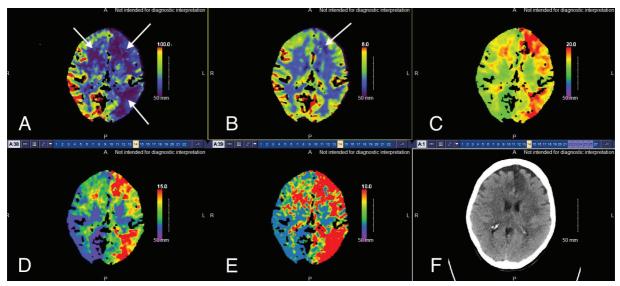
Computed tomography perfusion. This study was performed day 10 post aSAH. Overall, this study is consistent with severe reversible ischemia in multiple territories. Panel A (cerebral blood flow) shows reduced blood flow in the bilateral anterior cerebral artery and left middle cerebral artery territories (white arrows). The flow reduction is most severe on the left side. Panel B (cerebral blood volume) shows a small area of reduced blood volume (white arrow) consistent with infarction. However, for the most part, cerebral blood volume is preserved. Panels C-E are time parameters that all show significant delays consistent with ischemia in the same regions as the flow reduction in panel A. Panel F is a standard noncontrast CT head for comparison.
